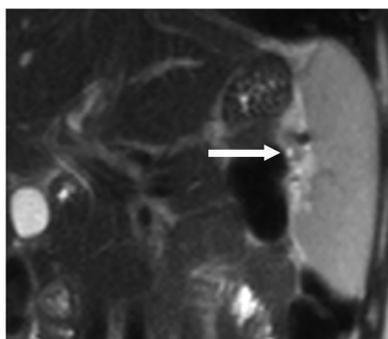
20-year-old woman with peritoneal carcinomatosis from ovarian tumor and splenic involvement. T2-weighted MR image in the coronal plane shows hyperintense sub centimeter tumor deposit (arrow) at the splenic hilum. The lesion was considered present by only one reader and overlooked by the other reader.
